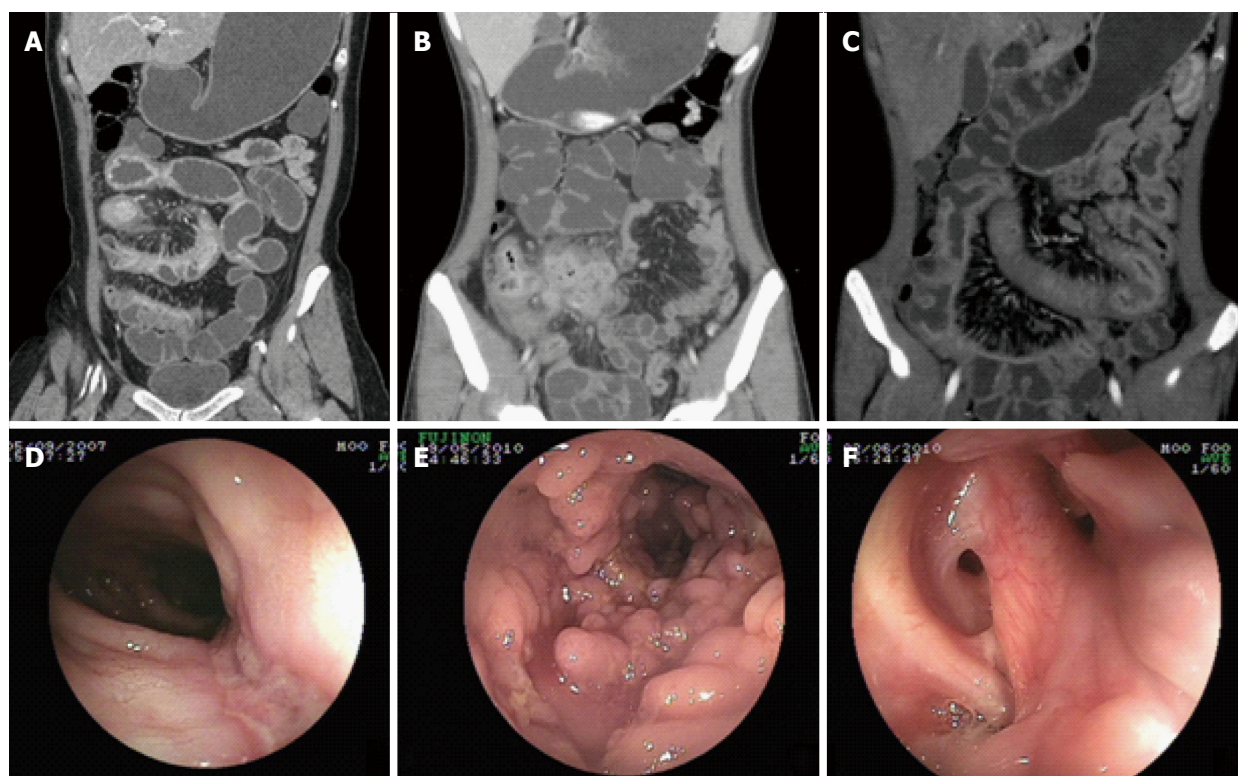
Endoscopic and computed tomographic enterography features in Crohn's disease. A: Coronary reconstructed CTE reflected stricture with proximal dilation and comb sign in ileum; B: Phlegmon in distal ileum; C: Stretching and densifying of distal mesenteric artery so-called comb sign in ileum; D: DBE found longitudinal ulcer in distal ileum; E: Colonoscopy detected Pseudo-polyps formation in ascending colon; F: Perianal involvement in CD.
